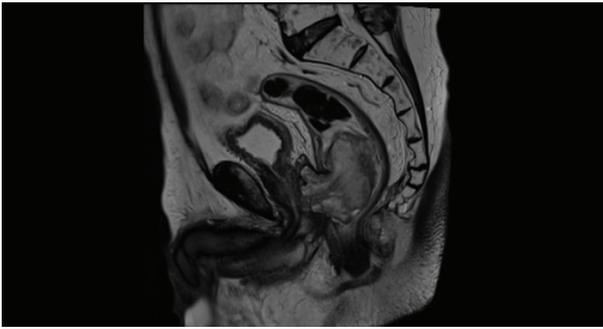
Pelvic magnetic resonance image of rectal mass
